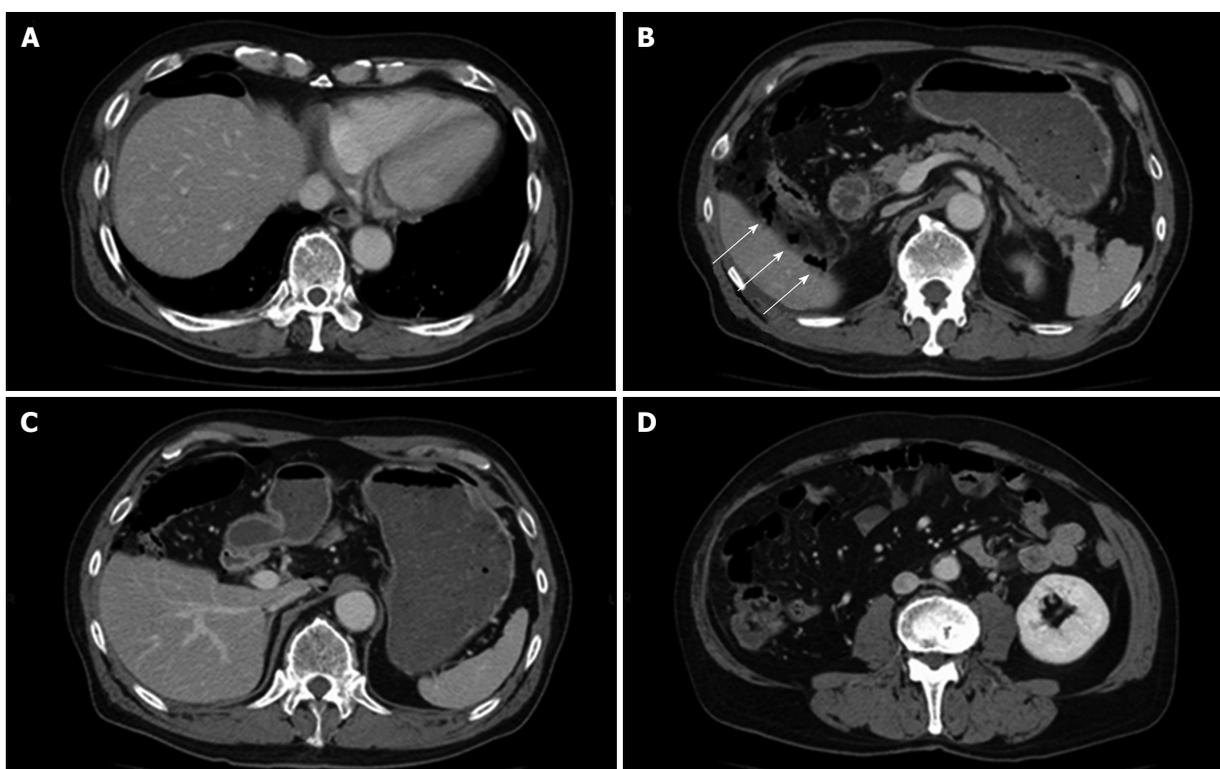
Abdominal computed tomography scan images of a man in his 70s who underwent endoscopic mucosal resection of a large polyp on the transverse colon. A: Free air and small ascites were recognized around the right lobe of the liver; B: Air density was recognized inside the adipose tissue around the ascending colon (white arrows); C: The stomach was fully occupied with food particles; D: Which had not yet reached the colon.
